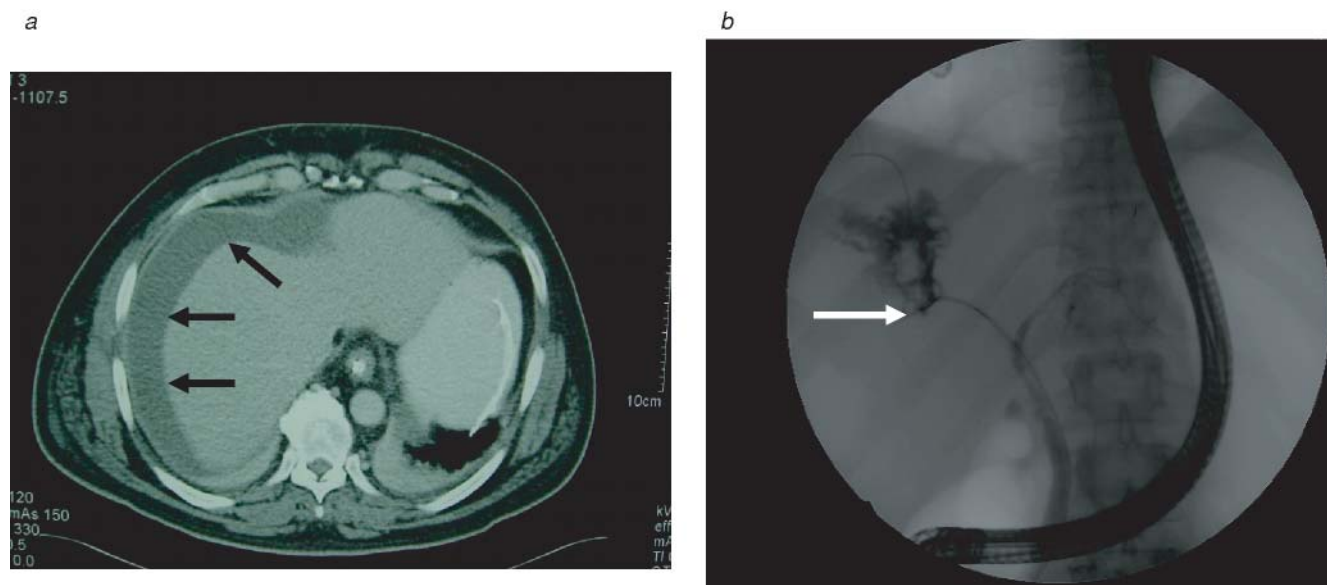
A biloma, evident on a computed tomographic scan (a), with an associated right hepatic duct injury evident on endoscopic retrograde cholangiography (b).
